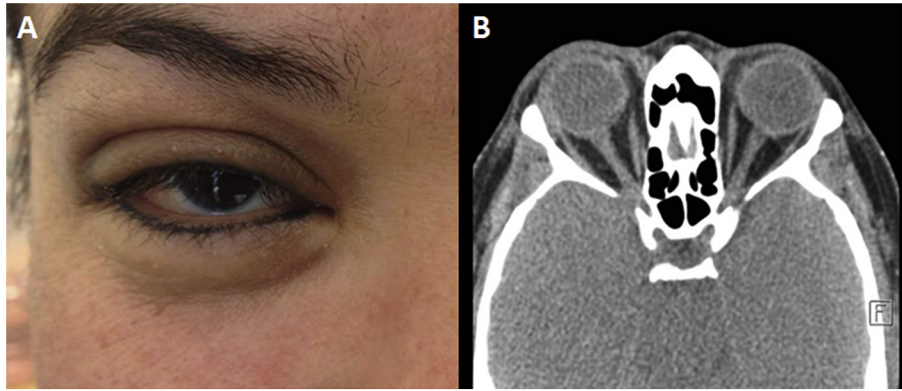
Clinical photograph, frontal view (A) and axial CT scan (B), taken at the patient's last office visit (18 months after surgery). The vision was 20/60, full range of ocular movements, good eyelid opening and no evidence of intraorbital gas.
